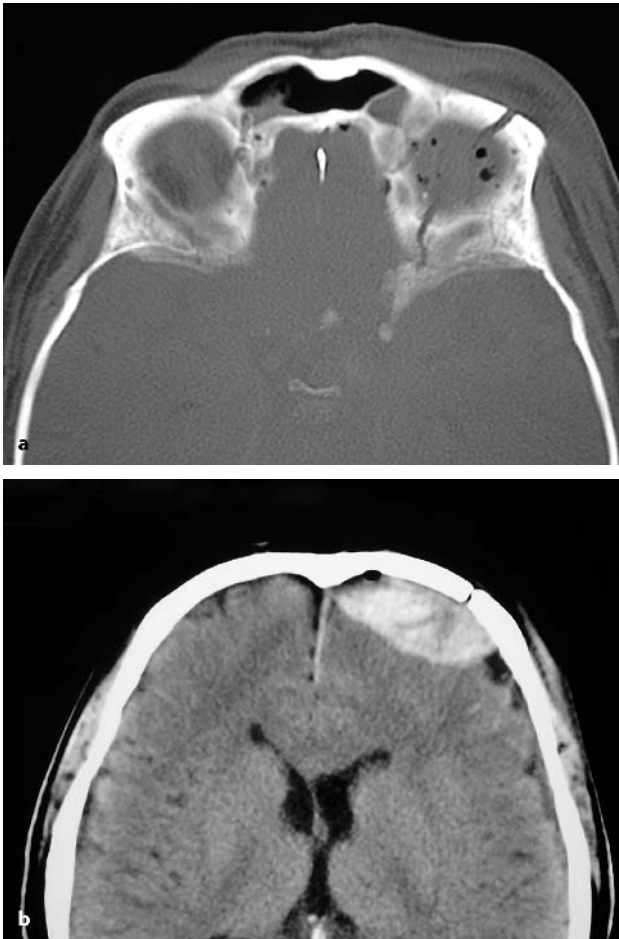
CT images of a trauma patient presenting with a fracture of the orbital roof (a) with secondary visual deficit in the same side and an associated intracranial hematoma above the orbit (b). This constellation allows decompressing the orbit and evacuating the hematoma during one surgery
